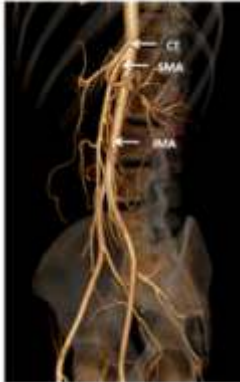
3D volume rendered image depicting origin of CT (celiac trunk), SMA (superior mesenteric artery) and IMA (inferior mesenteric artery) from the ventral surface of aorta.
